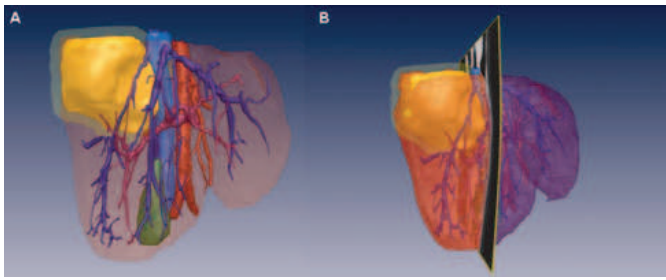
Planning of the surgical procedure by 3-dimensional reconstruction of CT scans.
